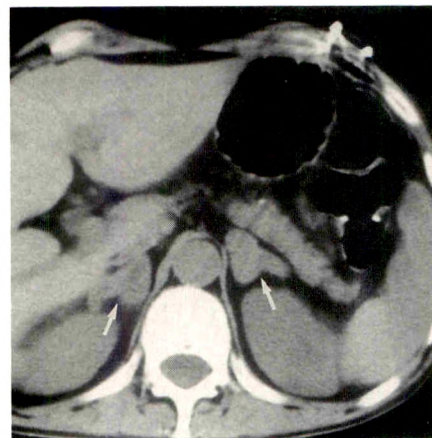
CT scan shows marked enlargement of right and left adrenal glands (arrows).
